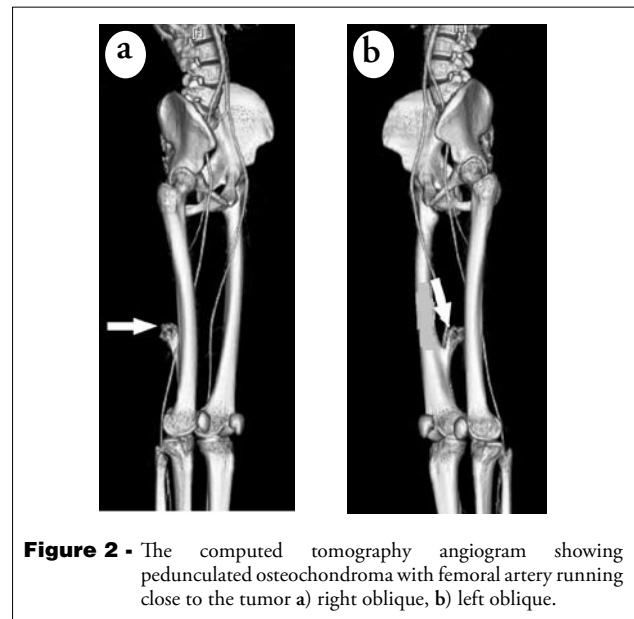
The computed tomography angiogram showing pedunculated osteochondroma with femoral artery running close to the tumor a) right oblique, b) left oblique.
